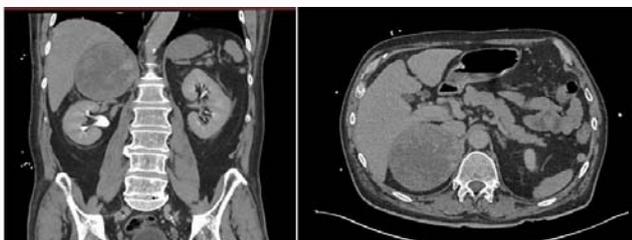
Coronal and transverse sections of the CT-scan, showing the well-encapsulated right adrenal lesion. On the right, image from the non-contrast series.
